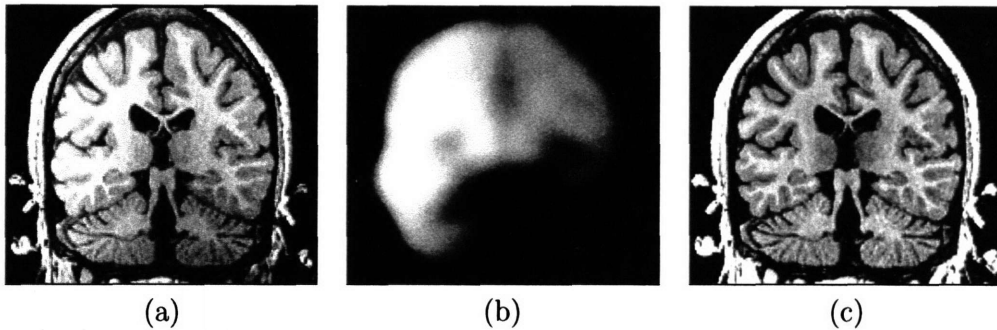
Image (a) shows an MR image corrupted by image inhomogeneities, noise, partial voluming and other image artifacts. The image inhomogeneities of (a) are shown in (b). Unlike noise, image inhomogeneities are characterized by a slowly varying values within the brain. Image (c) is as image inhomogeneity corrected MR image of (a).
